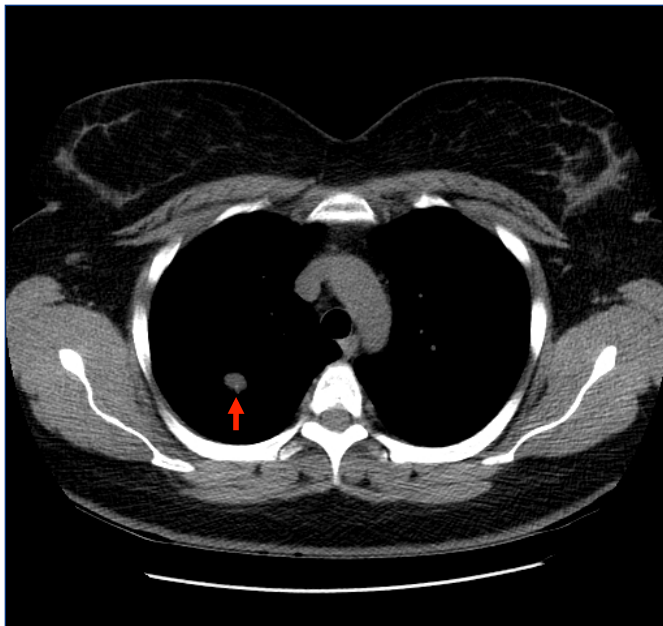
Axial non-contrast CT of the chest in lung windows re-demonstrates the 1.7 cm right upper lobe pulmonary nodule with circumscribed margins (red arrow). No evidence of emphysema.
